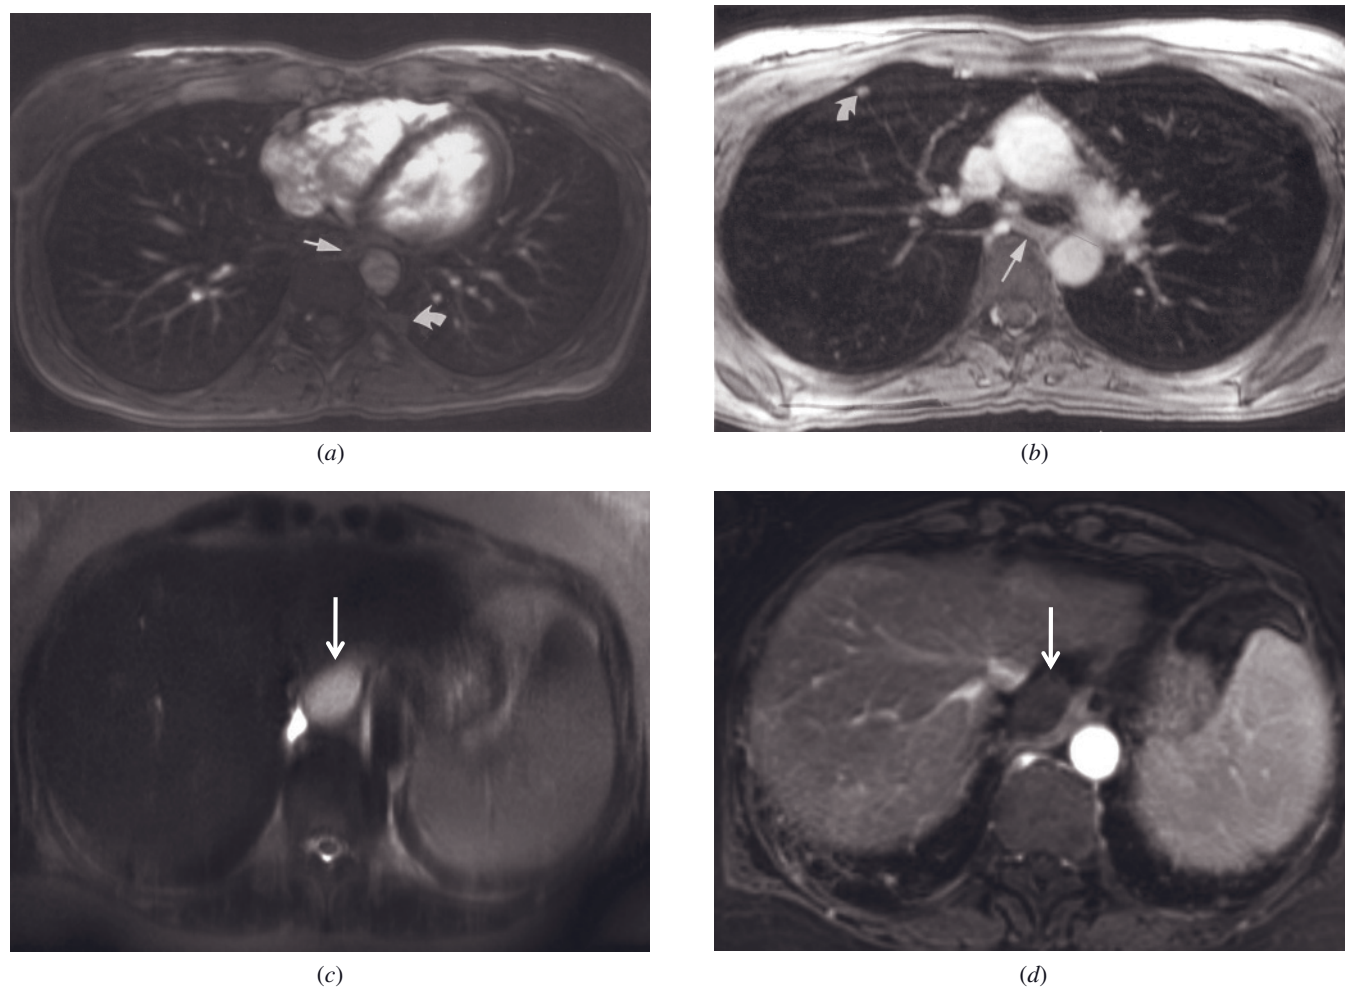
Normal esophagus. Transverse gadolinium-enhanced 3D gradient-echo (*a* and *b*) images in two patients. On gadolinium-enhanced 3D images, the esophagus is well shown (short arrows, *a*, *b*) and is free of cardiac motion artifact. Note also a subtle pleura-based density along the posterior left hemithorax (curved arrow, *a*) and pulmonary metastasis (curved arrow, *b*). Duplication cyst. T2-weighted single-shot echo-train spin-echo (*c*) and T1-weighted postgadolinium hepatic venous phase fat-suppressed 3D-GE (*d*) images at 3.0 T demonstrate a paraesophageal cyst (arrows, *c*, *d*), which shows high signal on T2-weighted image (*c*) and no appreciable enhancement on postgadolinium image (*d*).
